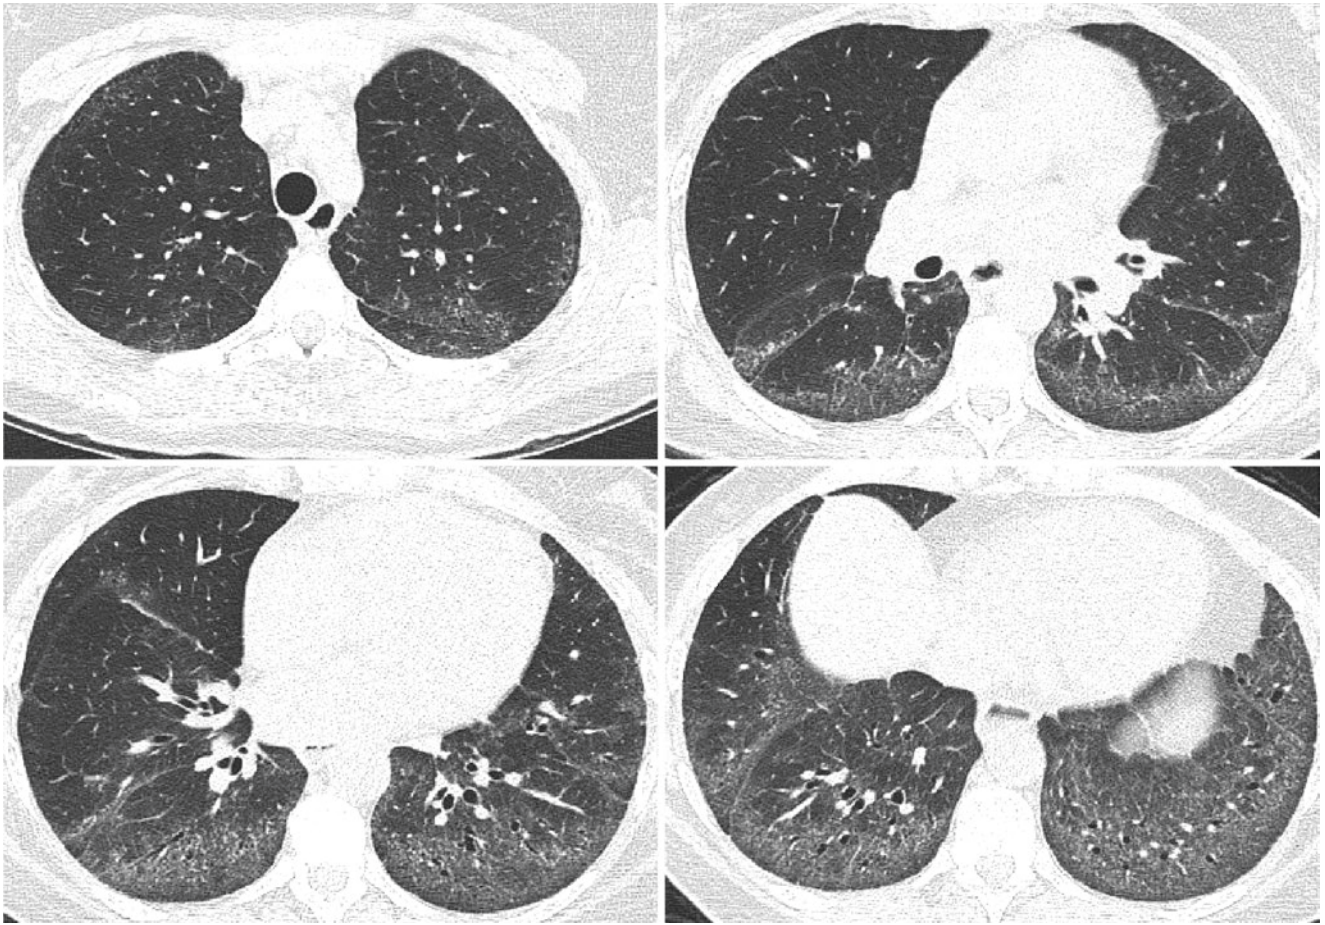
Transaxial chest CT in a patient with systemic sclerosis showing a pattern of nonspecific interstitial pneumonia, characterized by lower lung predominance of ground glass, reticulation, and traction bronchiectasis in a peripheral distribution, but with immediate subpleural sparing
